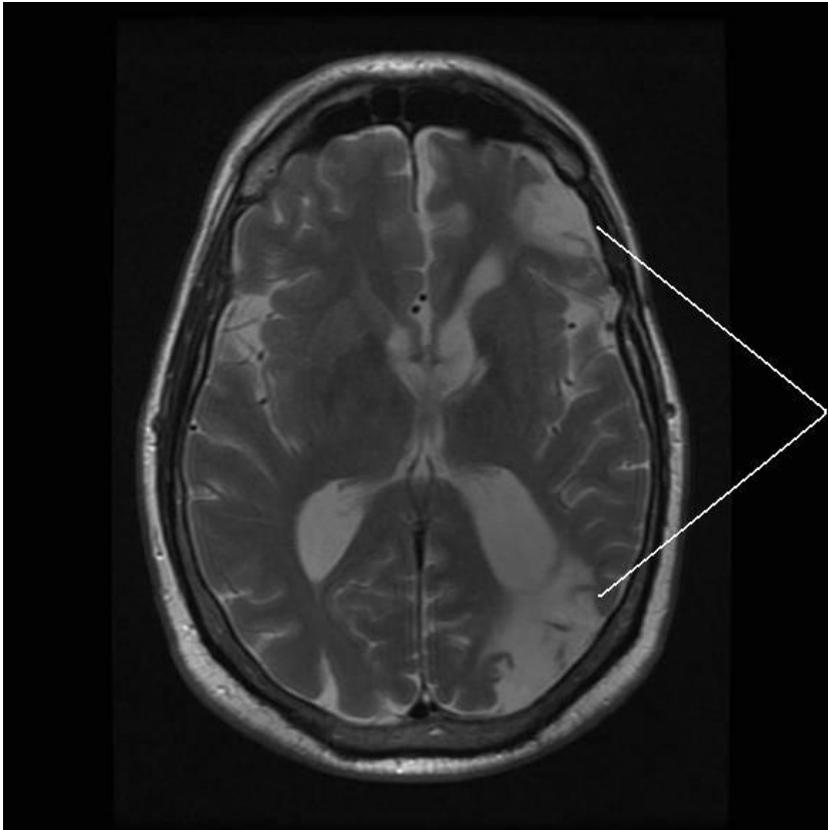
Primary CNS vasculitis. T₂-weighted MRI of the brain demonstrates left frontal and parieto-occipital lobe areas of infarction. Reproduced with permission from [10].
